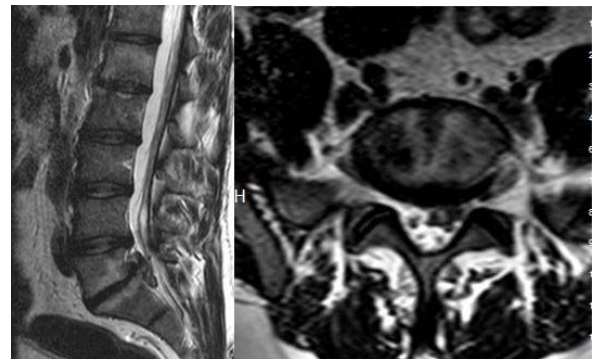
MRI revealed a large left sided prolapse of the intervertebral disc at the L5-S1 level.
